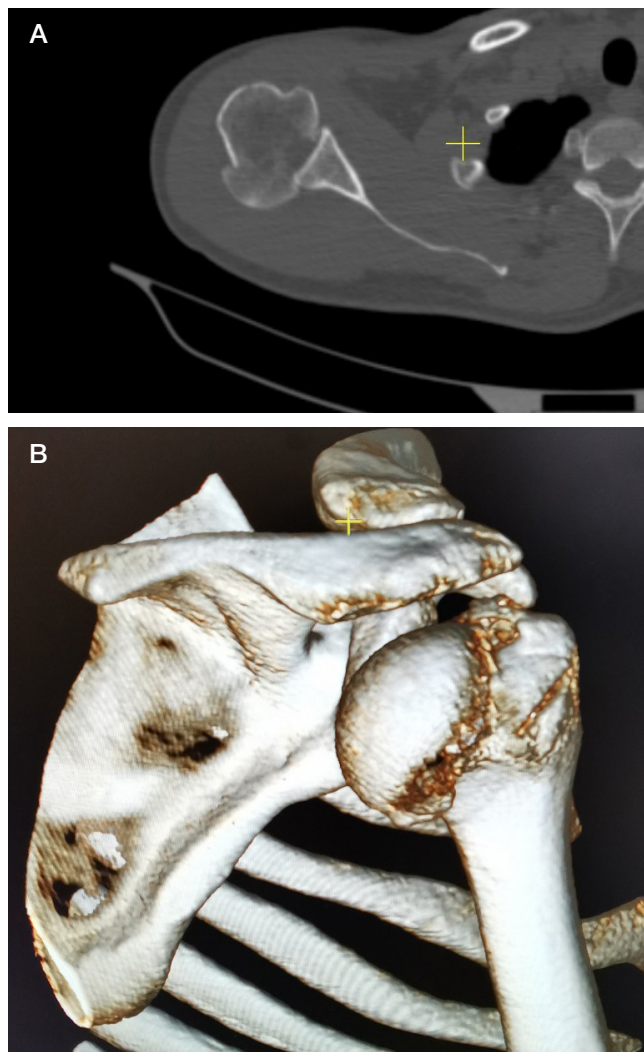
Axial computed tomography scan of the right shoulder joint 3 weeks after injury (A). Volumetric reconstruction of the proximal part of the right humerus 3 weeks after injury (B)
